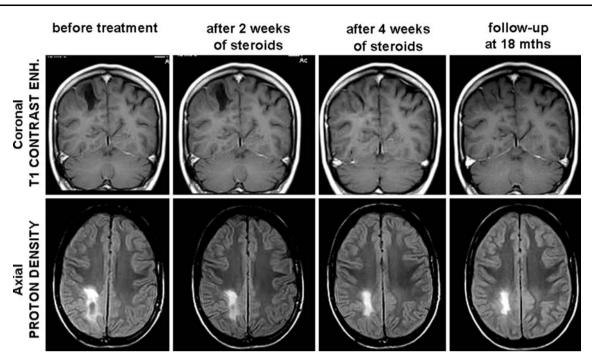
MRI follow-up: coronal T1 contrast-enhanced (a), and axial proton density (b), at different time points: before treatment, at 2 weeks of steroids, at 4 weeks of steroids and at follow-up after 18 months
